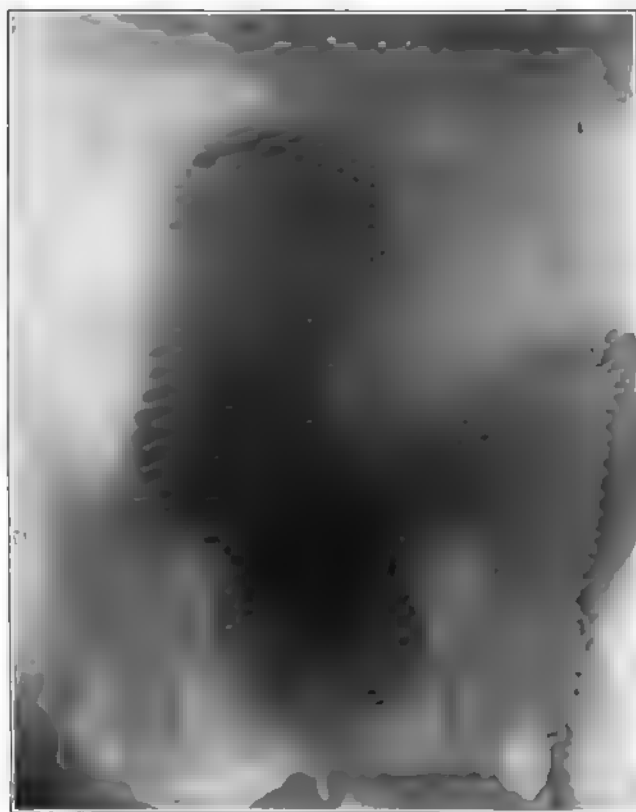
(A80,028, X-ray 19,406.) R. B. B., male, aged thirty-seven. Radiogram shows obstruction of descending colon and sigmoid, probably due to tumor. Exploration: Tumor of sigmoid 7 inches long fixed to the bladder and left side of pelvis. Inoperable carcinoma.
